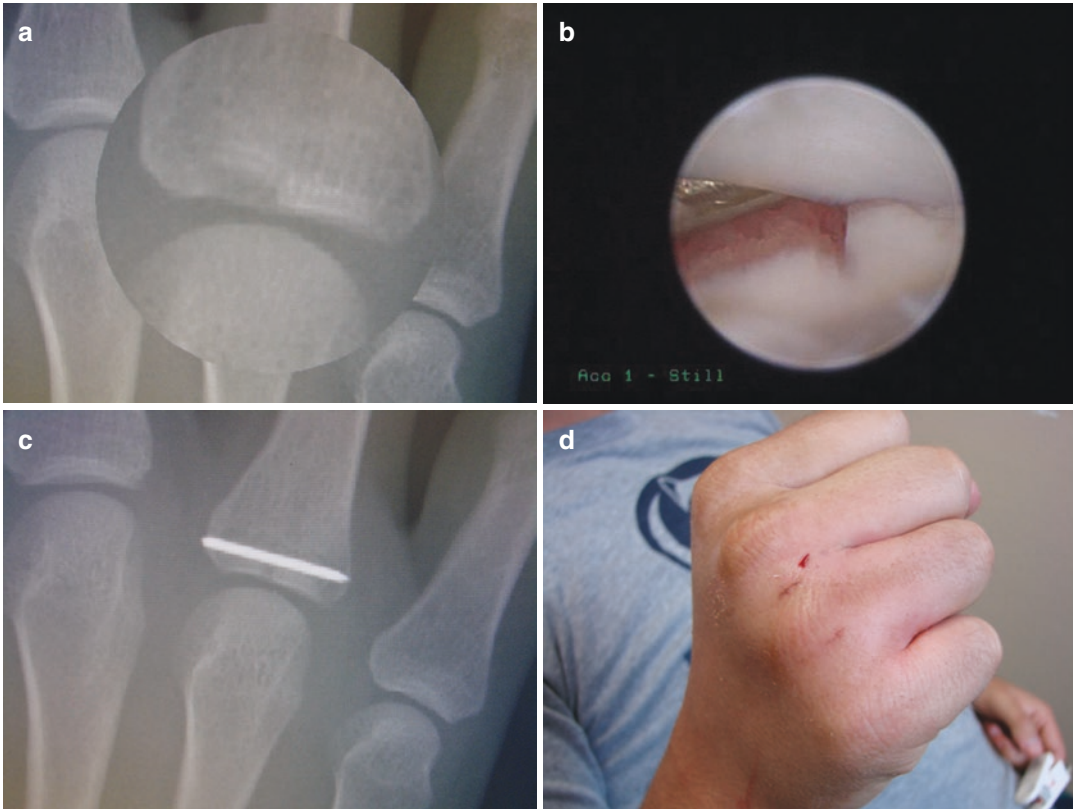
(a) Magnified radiograph showing proximal phalanx base diepunch fracture. (b) Proximal phalanx base FX being reduced by small JT hook probe. (c)
